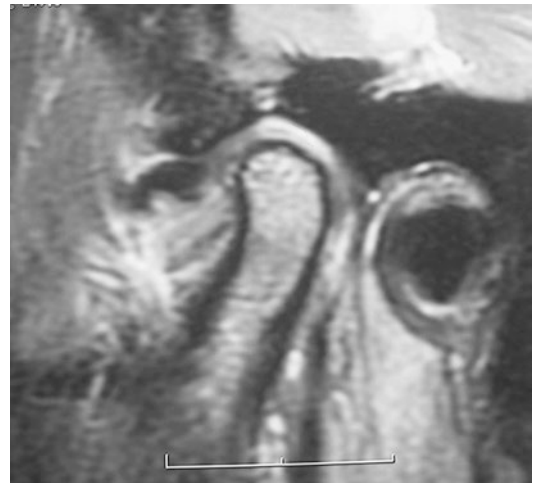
Category 3, Moderate TMJ Changes—MRI showing moderately displaced disc that still has the biconcave appearance suggesting it can be salvaged
